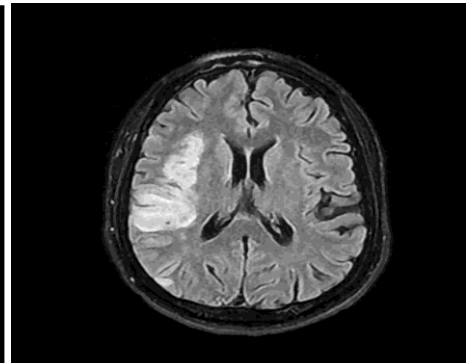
FLAIR images showing acute infarct in right middle cerebral artery territory
